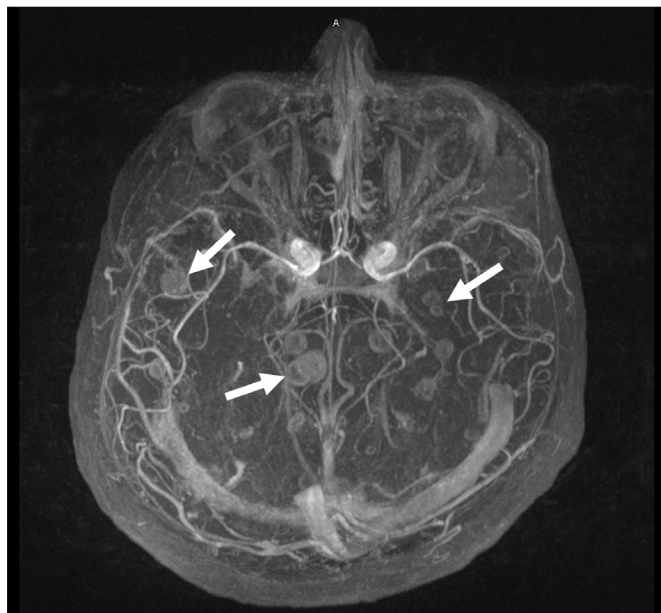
Brain CT scan showing multiple rounded masses distributed throughout the cerebral cortex (arrows) compatible with multiple tuberculomas.
